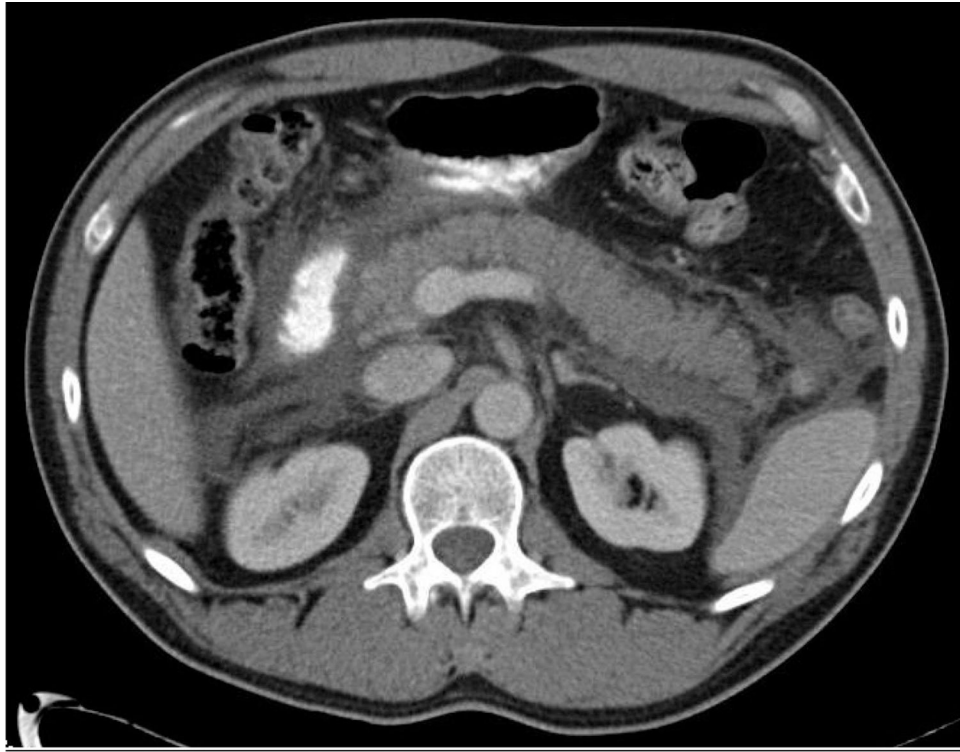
Contrast enhanced computed tomography of a patient presenting with acute pancreatitis from gallstone disease. CT demonstrating characteristic imaging findings of interstitial edematous pancreatitis, with a heterogeneously enhancing, edematous pancreas.
